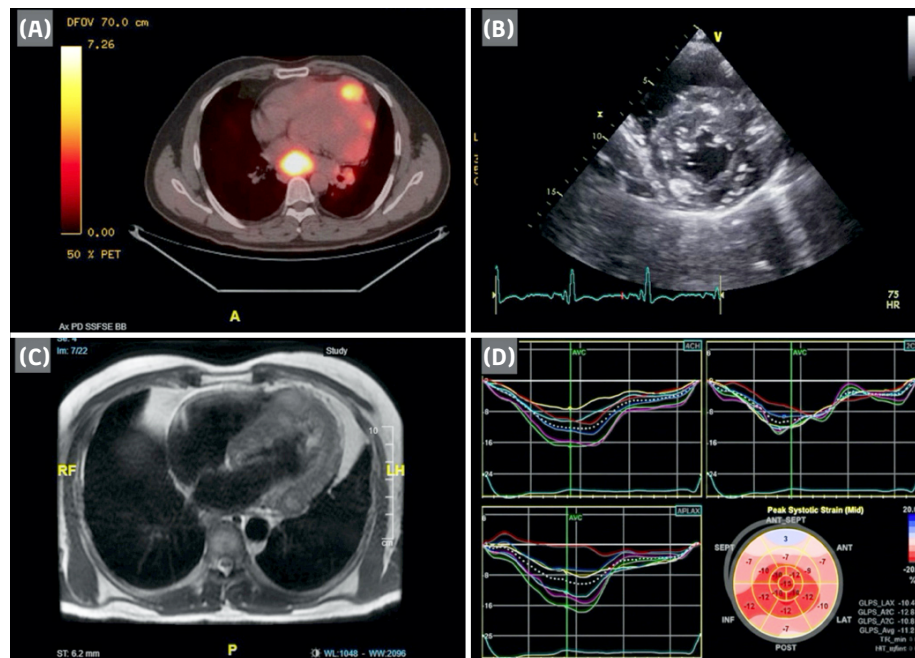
Pre-treatment multimodality imaging of cardiac metastases from a neuroendocrine tumor. (A) Baseline axial fused fluorodeoxyglucose positron emission tomography (FDG-PET) image demonstrating multifocal intense myocardial FDG uptake, predominantly involving the left ventricle. (B) Parasternal short-axis transthoracic echocardiography showing multiple intramyocardial hyperechoic masses. (C) Black-blood spin-echo cardiac magnetic resonance image revealing diffuse intramyocardial metastatic infiltration, most prominent in the basal anterolateral wall. (D) Baseline two-dimensional speckle-tracking analysis showing reduced myocardial tissue deformation, particularly in the basal anteroseptal region (global longitudinal strain: -11.2%).
